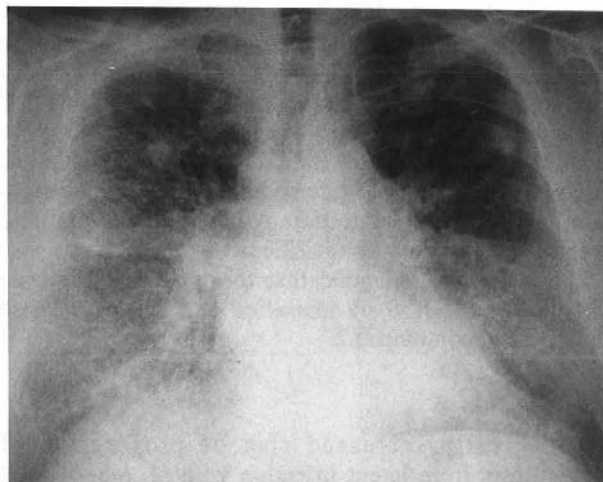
Chest radiograph: diffuse interstitial infiltration of lungs predominantly in lower parts in association with nodular lesions.
